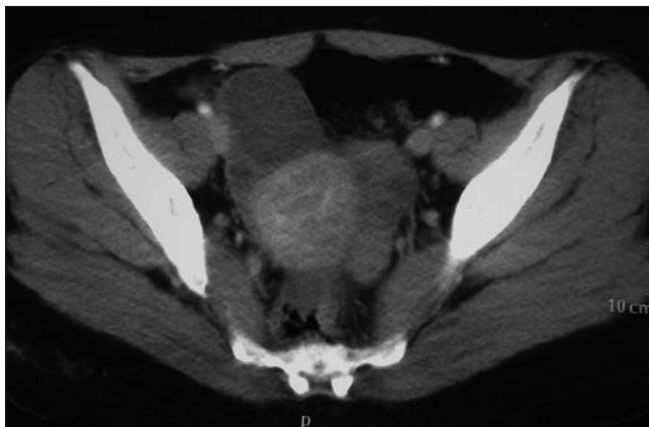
Adnexal cyst demonstrated in the pelvic computed tomography scan
